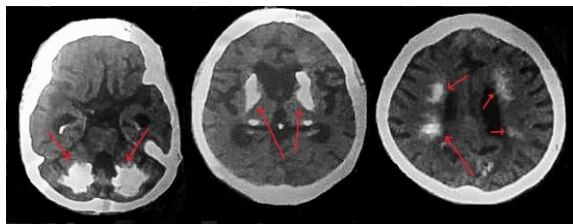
Plain Computed Tomography scan of the head showing bilateral calcification in various regions of brain.
